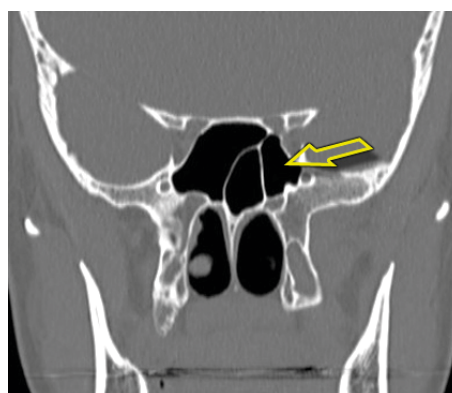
A computed tomography scan of the paranasal sinuses, frontal section. The Onodi cell is marked on the left side.
